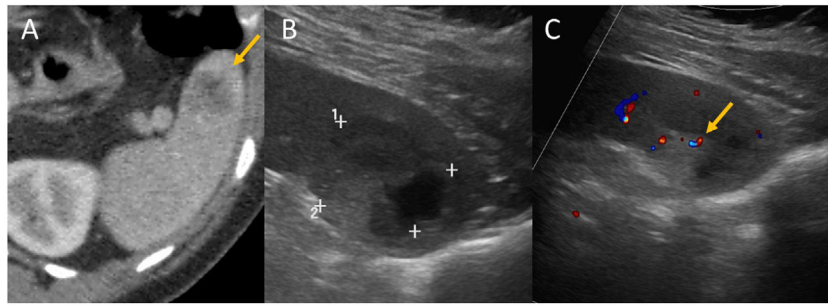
66-year-old woman. History of operated-on ovarian serous carcinoma under follow-up. Patient has a pacemaker, so magnetic resonance imaging contraindicated. (A) Axial computed tomography with contrast with finding of a splenic lesion showing a slight increase in size with respect to previous scans (yellow arrow). (B) Baseline grey scale ultrasound showing a mixed solid-cystic lesion (shown between cursors) (C) Colour Doppler ultrasound showing vascularisation within the lesion with presence of chaotic vessels (yellow arrow).
